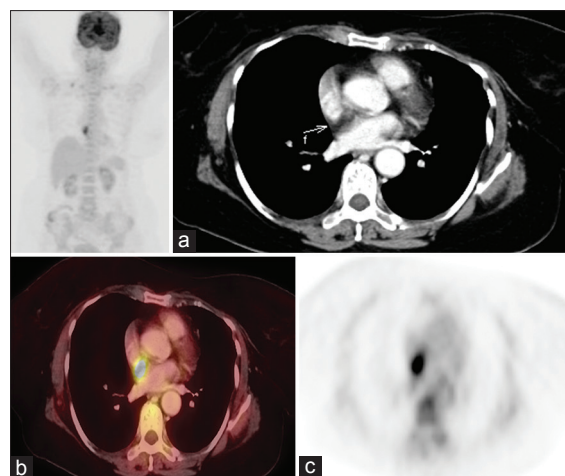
Focal 18F-fluorodeoxyglucose activity with standardized uptake value measuring 14 was noted in the mediastinum on wholebody positron emission tomography/ computed tomography. (a) An unenhanced axial computed tomography scan with an arrow showing the fat density in the interatrial septum. (b) Axial fused and (c) Axial positron emission tomography image
